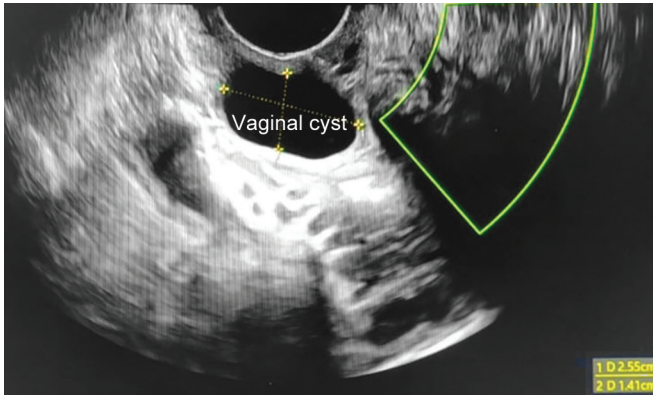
Transvaginal ultrasound showing vaginal cyst
